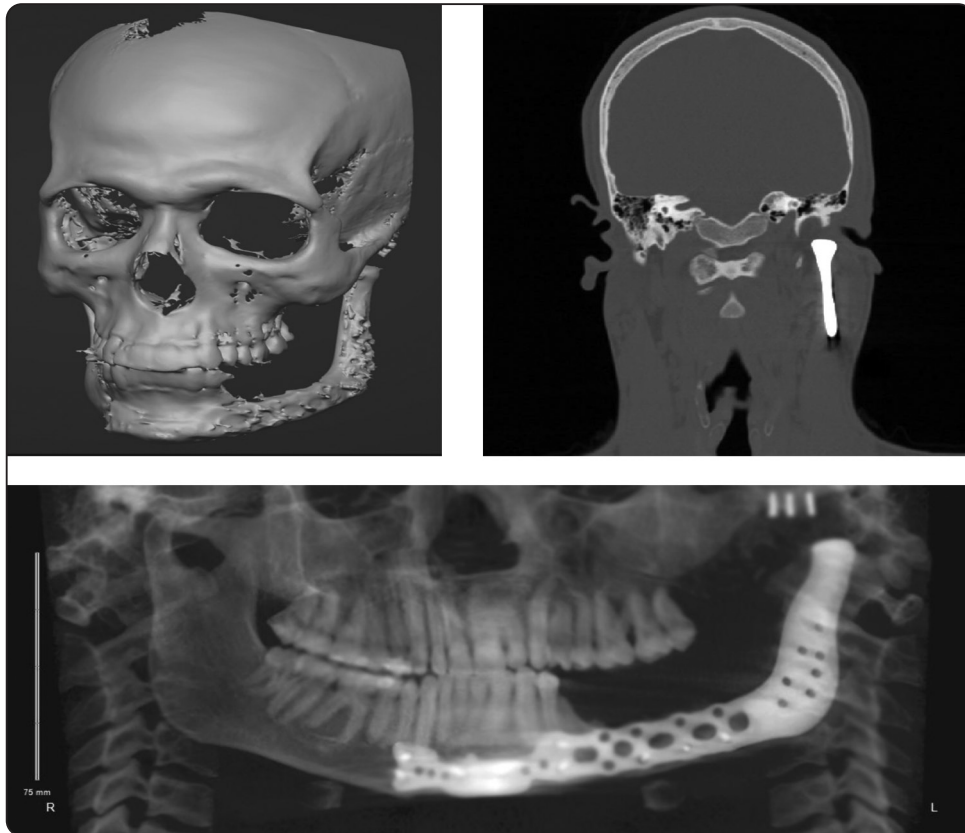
Showing 3D reconstruction, coronal view and panoramic CT view after the 5-year follow-up.
